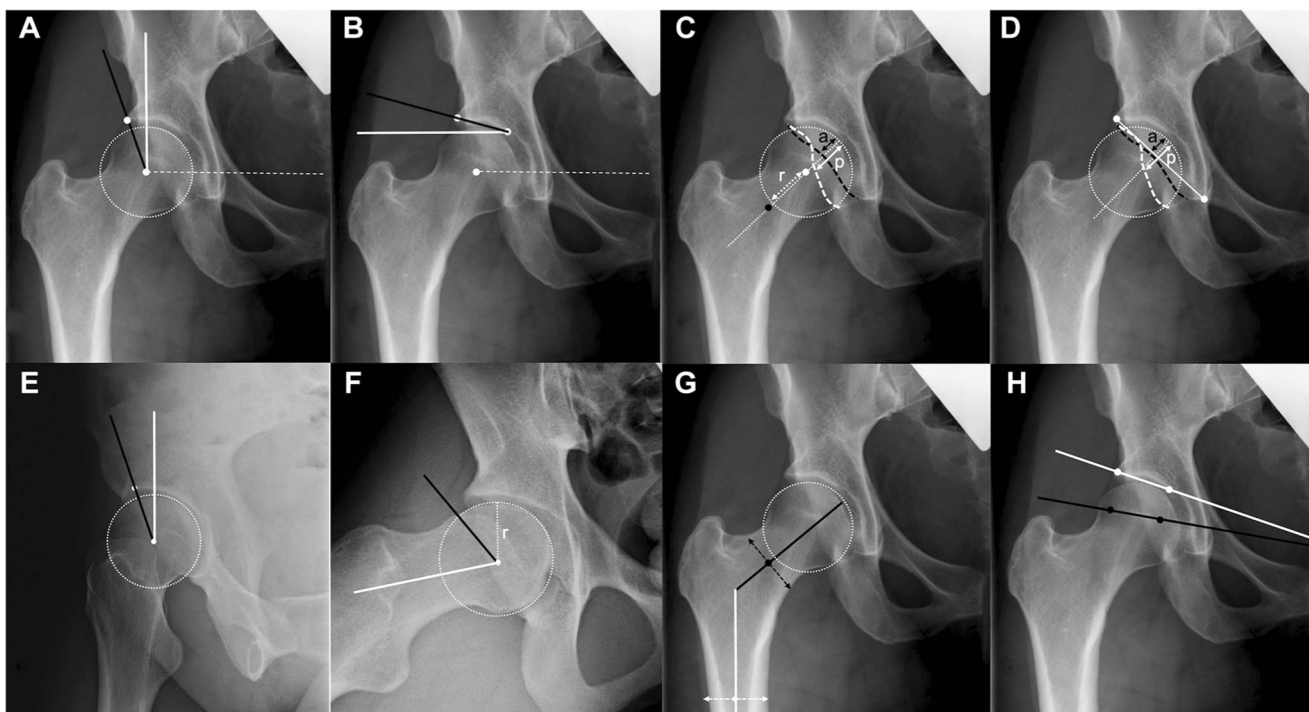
Radiographic features of the proximal femur and acetabulum relevant to the diagnostic evaluation of borderline dysplasia. a Lateral center-edge angle (LCEA): angle formed between a perpendicular line (white line) to the line that connects the center of the femoral heads (white dashed lines) and a line (black line) that connects the center of the femoral head to the most lateral point of the acetabular sourcil. b Tönnis angle: angle formed between a line (black line) drawn between the most lateral and most medial points of the acetabular sourcil and a parallel line (white line) to the line (white dashed line) connecting the center of the femoral heads. c Anterior wall index (AWI) and posterior wall index (PWI): the femoral neck axis (white dashed line) is drawn from the midpoint of the neck to the center of the femoral head. The radius (*r*) of the femoral head is drawn (dashed white arrow) in line with the axis of the femoral neck. The point at which the axis of the femoral neck passes through the anterior wall and the point at which the axis of the femoral neck passes through the posterior wall are marked. The AWI is calculated by dividing distance “*a*” (black arrow) by the radius of the femoral head. The PWI is calculated by dividing distance “*p*” (white arrow) by the radius of the femoral head. d Posterior to anterior wall (P/A) index: the most lateral aspect of the acetabulum and the most inferior point of the tear drop point are connected by a line (solid white line), and a perpendicular line (white dashed line) is drawn at its midpoint. The acetabular articular surface is marked (white dashed circle). The distances from the anterior (black arrow) and posterior (white arrow) walls to the acetabular articular
